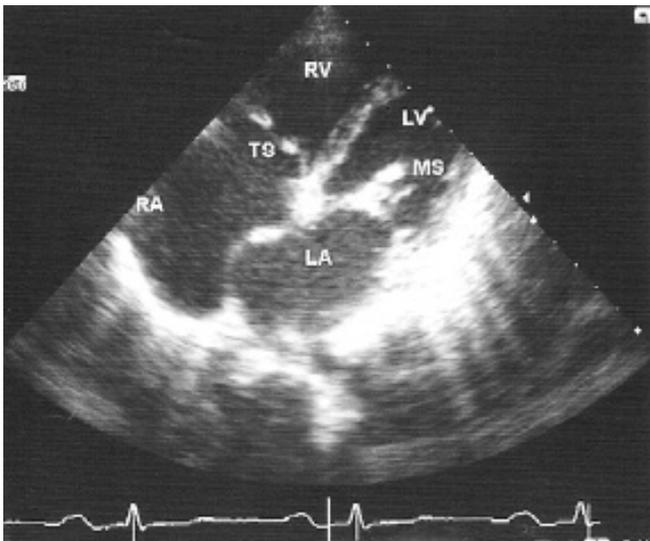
Apical four-chamber view recorded from slightly medial position showing thickened tricuspid leaflets with diastolic doming. Mitral leaflets are also thickened.
